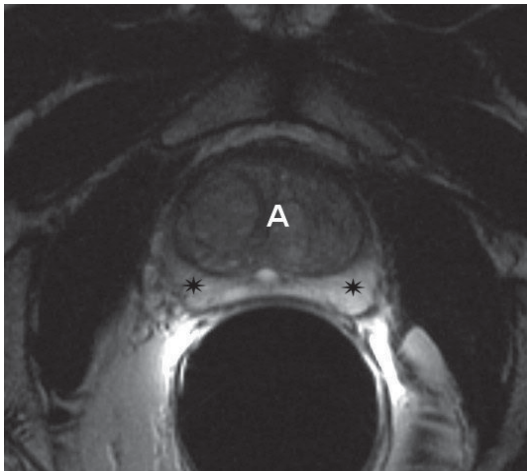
Magnetic resonance. Axial T2-weighted image. Prostatic adenoma. In the central portion of the adenoma (*A*) a heterogeneous multinodular structure can be discerned with initial compression on the peripheral zone (*asterisks*), from which it is well differentiated
